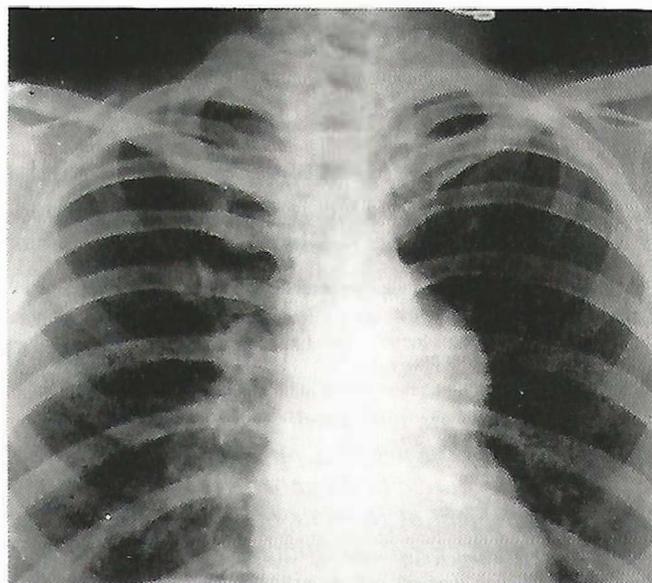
PA Chest radiograph shows a mediastinal mass projecting to the left of aortic arch and main pulmonary artery.
